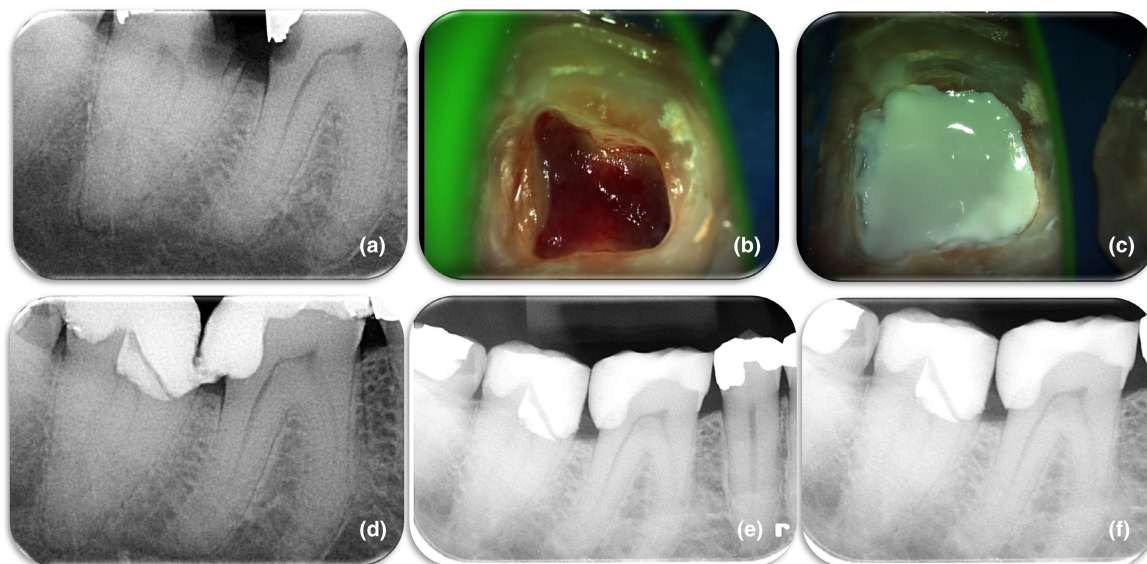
(a) Initial radiograph of a mature second mandibular molar of a 54-year-old patient with extremely deep caries and symptoms of lingering pain to cold stimulus. Deep caries is also present at the distal surface of the first molar (b). Control of bleeding, the tissue is ready for capping, (c) Placement of Total Fill BC over the coronal pulp tissue, (d) Postoperative radiograph of the case. Caries in first molar has been removed (e) 6-month recall radiograph, sufficient restorations have been placed in both teeth (f) 36-month recall radiograph, the patient is symptom free, and the teeth are fully functional.
